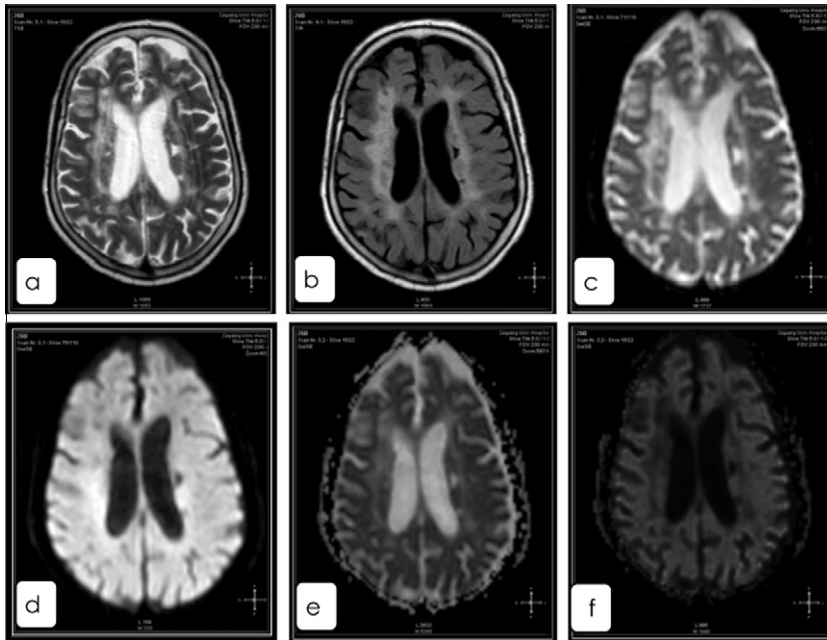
Multiple hyperacute right periventricular infarctions after 5 h of symptoms. The lesions cannot be detected at axial T2WI (a), FLAIR (b) and DWI-b = 0 (c) however at DWI-b = 1000 (d) they display marked hyperintensity, and low signal intensity at ADC map (e). The lesions display high signal intensity at exponential image (f) denoting hyperacute infarction. Another associated left periventricular chronic lacunar infarct which is of high SI at T2WI, FLAIR, DWI-b = 0 and ADC map, intermediate signal intensity at DWI-b = 1000 and low SI at exponential image denoting chronic infarction.
